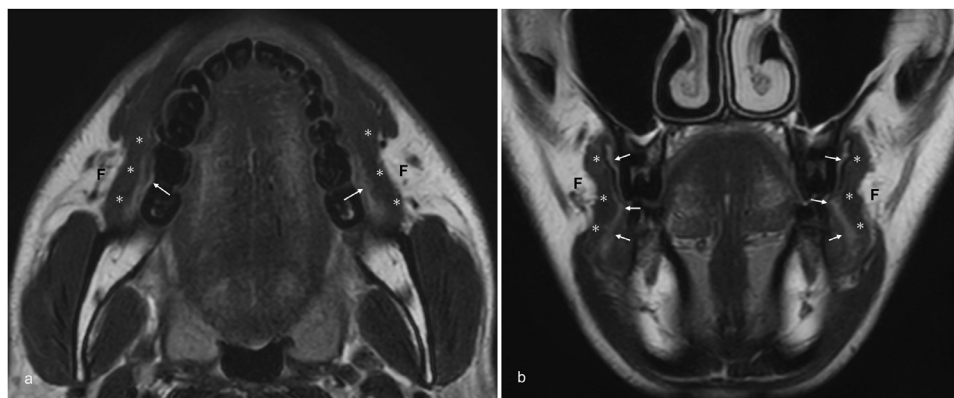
Normal anatomy of the buccal mucosa, buccinator muscle, and buccal fat pad. A 35-year-old male. (a) Axial and (b) coronal T2-weighted images show normal buccal mucosa (arrows), buccinator muscle (*), and buccal fat pad (F).
